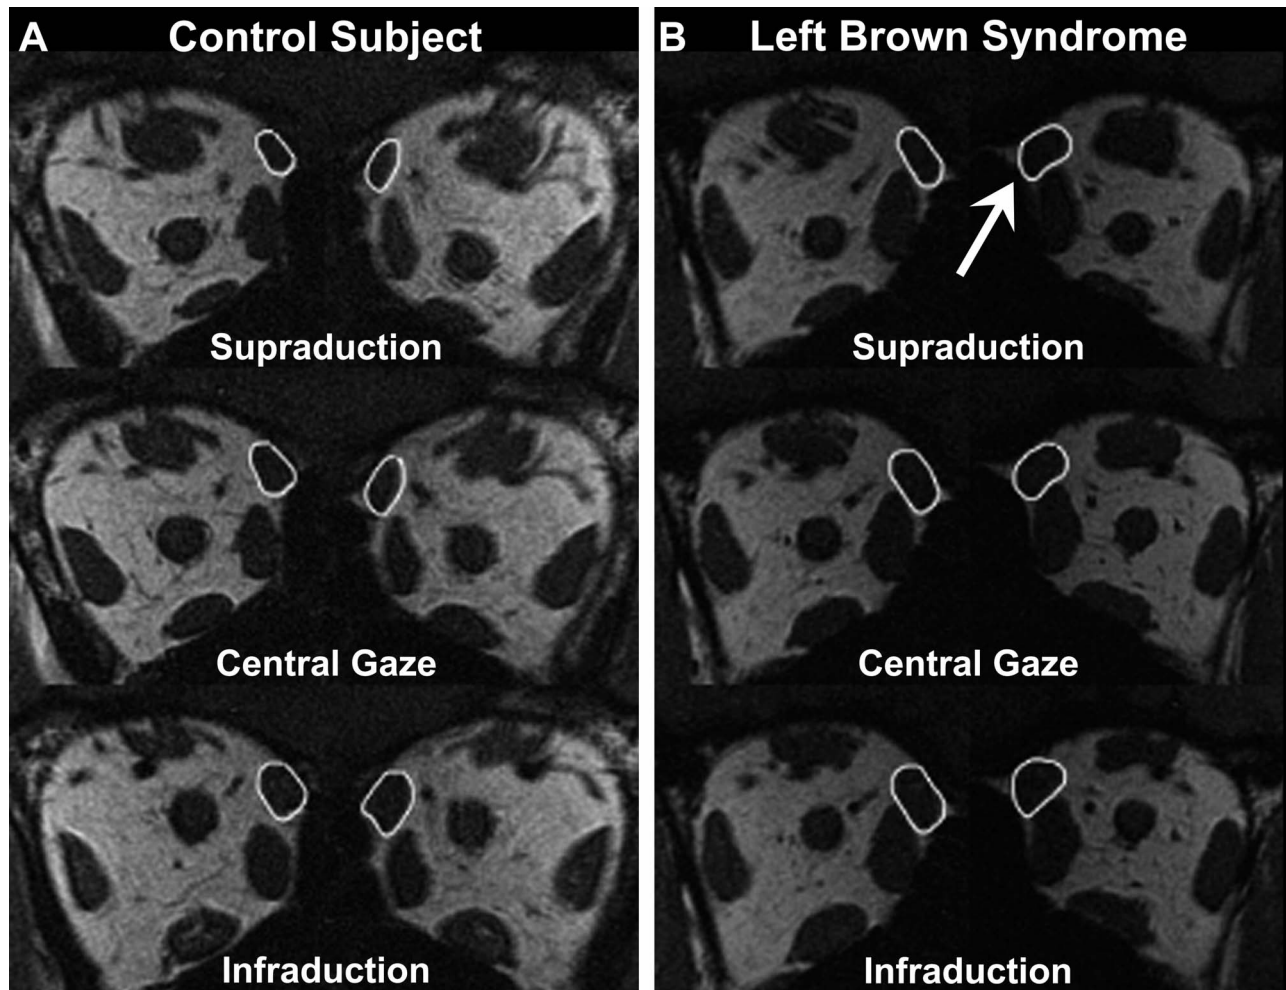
Quasi-coronal MRI of orbits in left control subject (A) and in BrS (B). Arrow indicates absence of reduction in left SO cross-section in supraduction.
